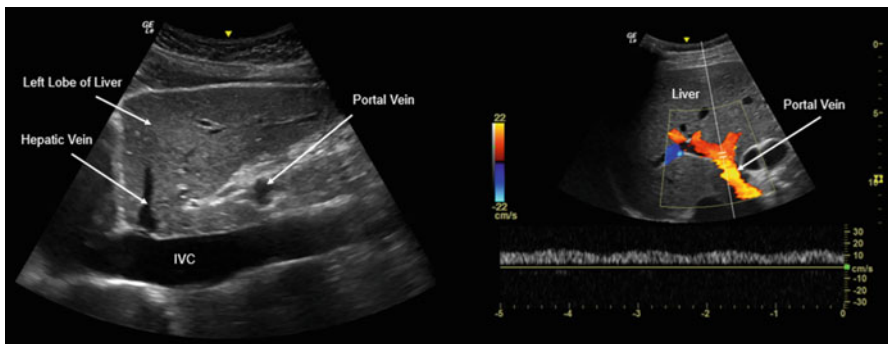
Blood vessels of the liver can be easily visualized in ultrasound. In the image on the left, the left hepatic veins can be seen draining into the IVC. The image on the right demonstrates the portal vein with color Doppler. Note that that the portal vein brings blood into the liver
